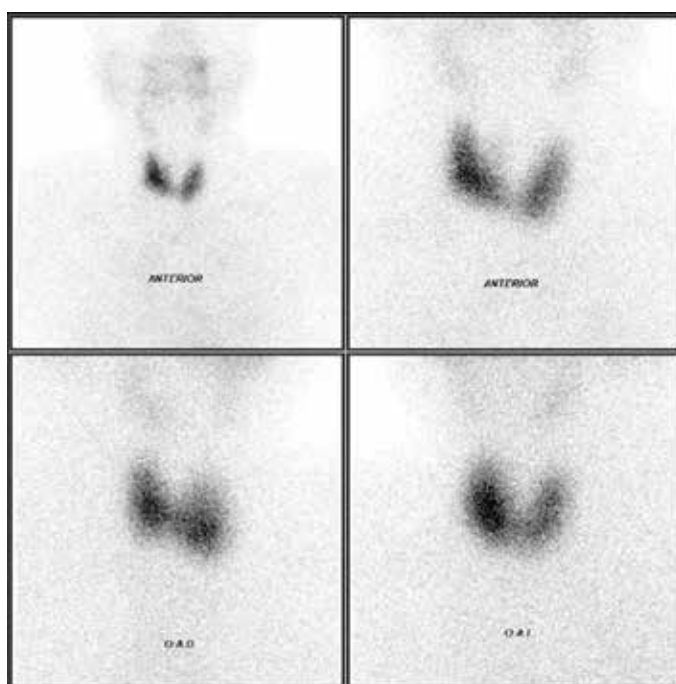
Thyroid scintigraphy shows an uptake-tracer nodule at the base of the right thyroid lobe and another non-functioning nodule at the base of the left thyroid lobe. *Courtesy of H.R.U. Málaga, Spain. Nuclear Medicine Department.*
